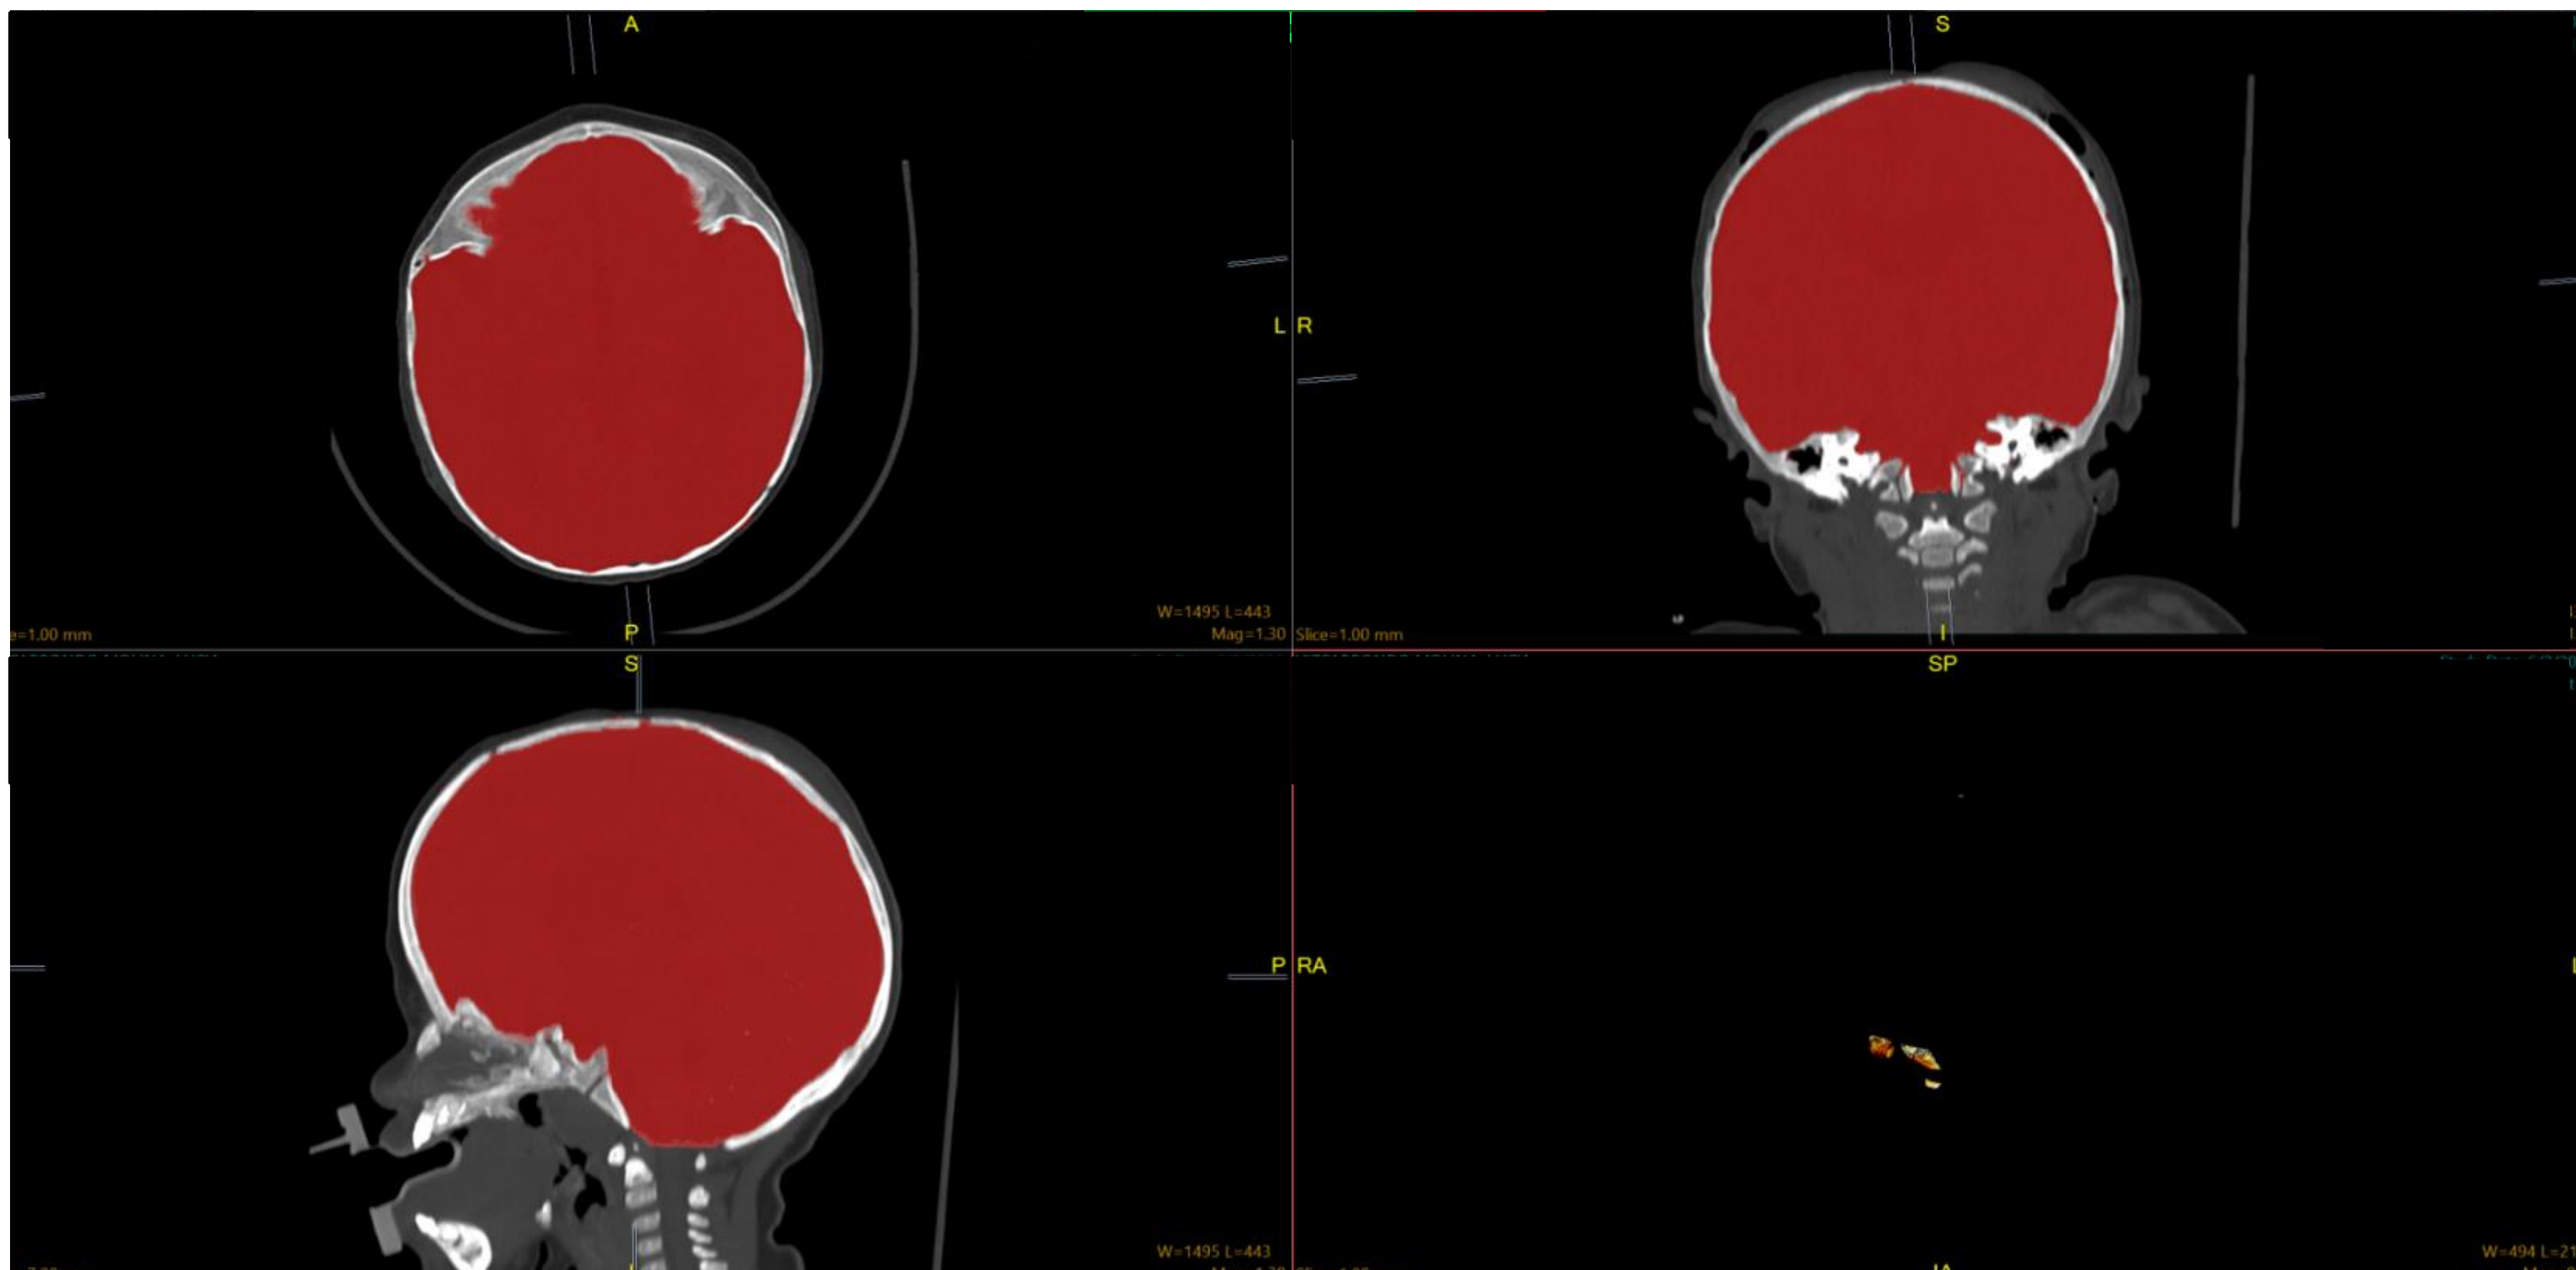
CT-derived intracranial volume measurement using VisAR (NOVARAD). Red shading indicates measured intracranial volume across axial, coronal, and sagittal views.
